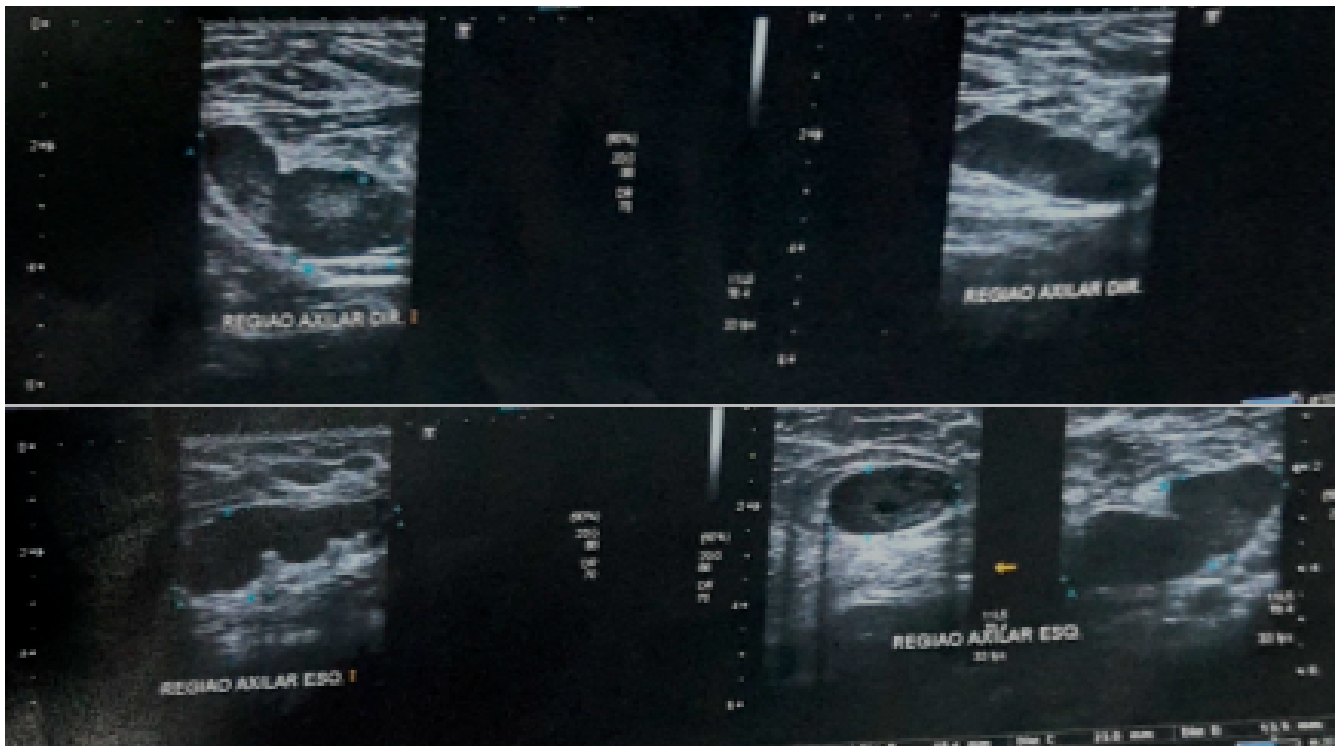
Right (upper) and left (lower) axillary ultrasound performed on April 25, 2019. Lymph nodes increased in size are seen bilaterally, with thickening of the cortex and displacement of the fatty hilum to the periphery. Category 4 (BI-RADS).
